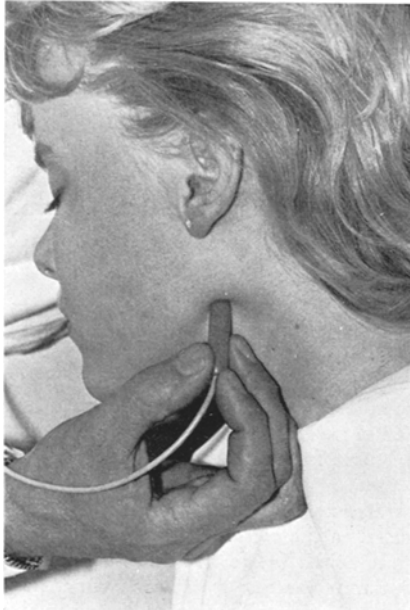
Ultrasound probe position below mandibular angle for the detection of signals from the internal and external carotid arteries
